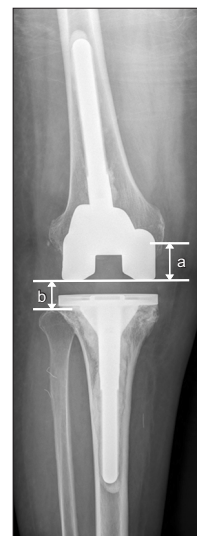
Measurement of the joint line. Joint line height (JLH) was measured from the medial femoral epicondyle (a) or the fibular head (b) on an anteroposterior standing X-ray, with the knee in a fully extended neutral position. JLHs were similar before and after revision total knee arthroplasty.
